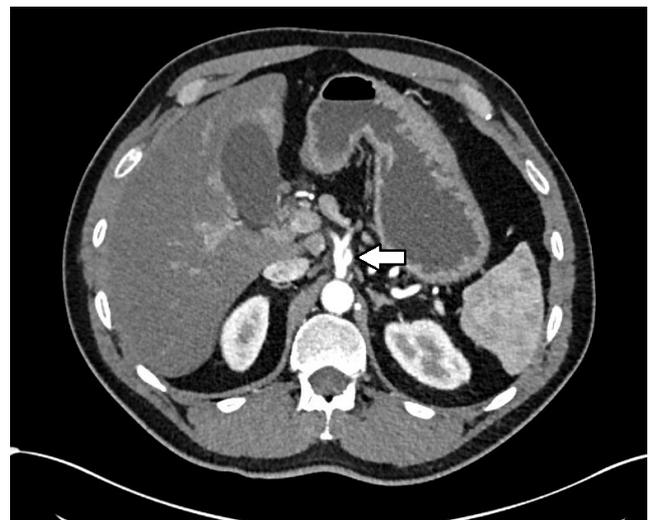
CT abdomen pelvis with contrast showing short segment dissection and pseudoaneurysm measuring 1.2 cm of the proximal celiac artery.
